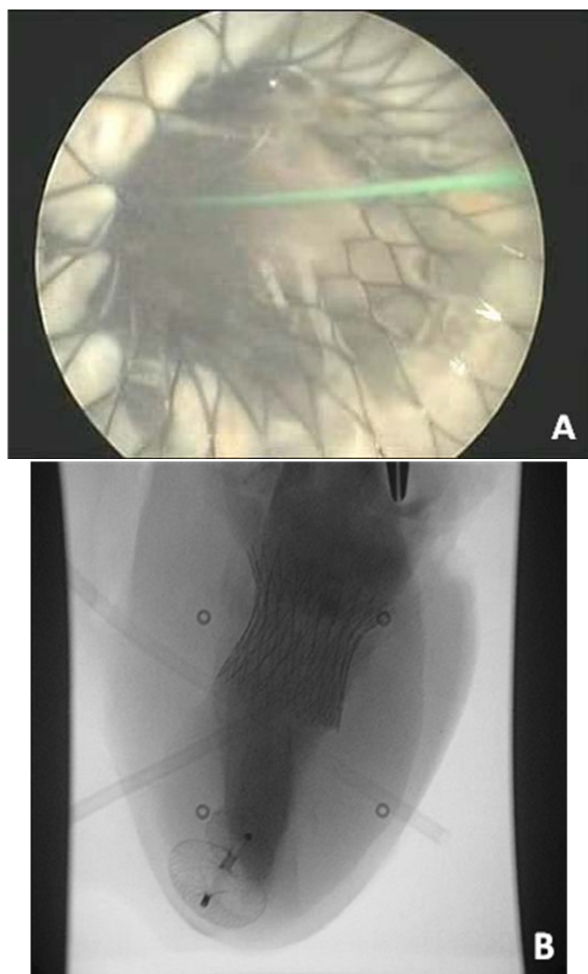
A: Stent position under endoscopy. B: Stent position under X-ray.
